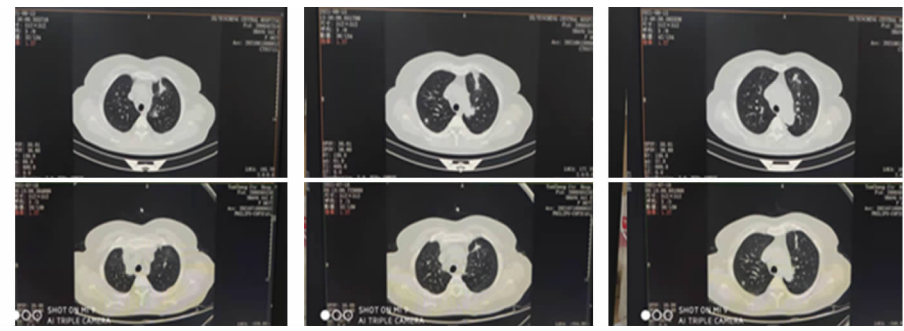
为患者急性髓系白血病 M2 化疗后出现肺部感染,两性霉素 B 治疗 22 天复查肺部 CT 效果明显
